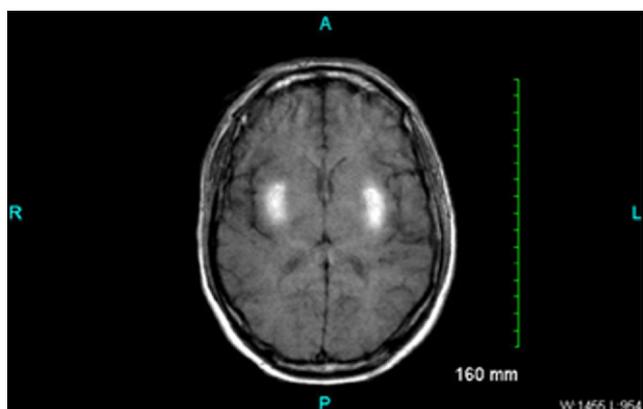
T1-weighted magnetic resonance image showing increased signal in the bilateral putaminal areas of the brain.
